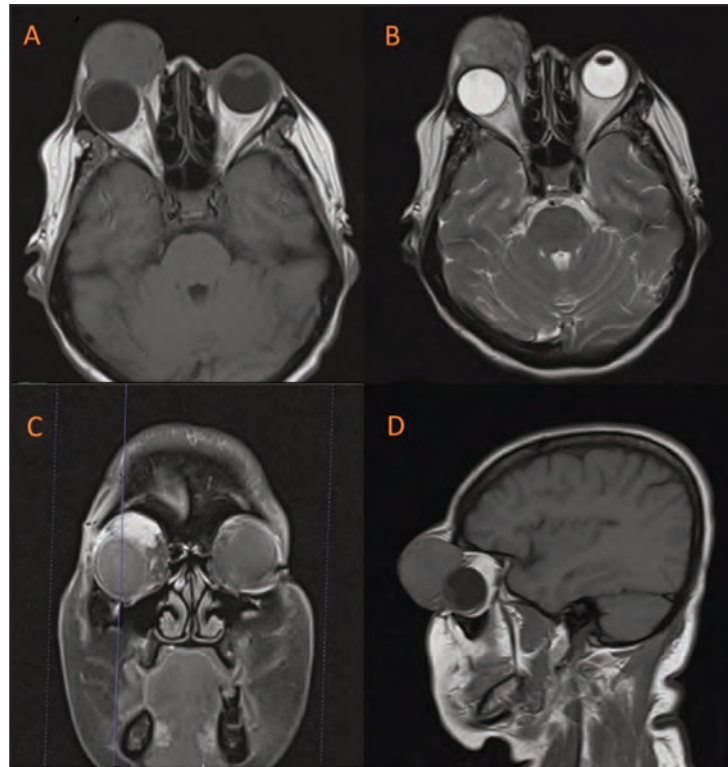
The axial section of the orbital MRI scan shows a focal, well-defined soft tissue mass at the anteromedial aspect of the right periorbital region, demonstrating isointense signal on T1-weighted imaging (A) and heterogeneous intermediate signal intensity relative to grey matter on T2-weighted imaging (B). The coronal section of the MRI shows part of the mass causing displacement of the right eye globe inferolaterally (C). The sagittal section of the MRI shows the mass causing displacement of the right eye globe posteriorly (D)
